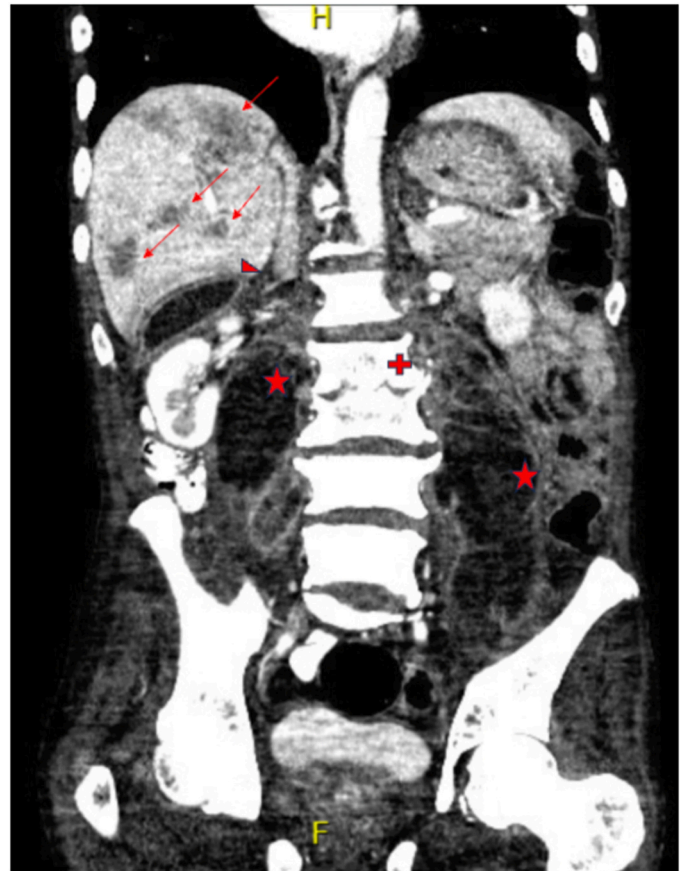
CT abdomen coronal view demonstrating numerous hepatic abscesses (arrows) in addition to a 43 mm × 78 mm subhepatic fluid collection (arrowhead), bilateral psoas abscesses measuring up to 57 mm × 50 mm x 157 mm on the left (star), and L2-L3 disc space erosion and destruction consistent with discitis and osteomyelitis (cross).
